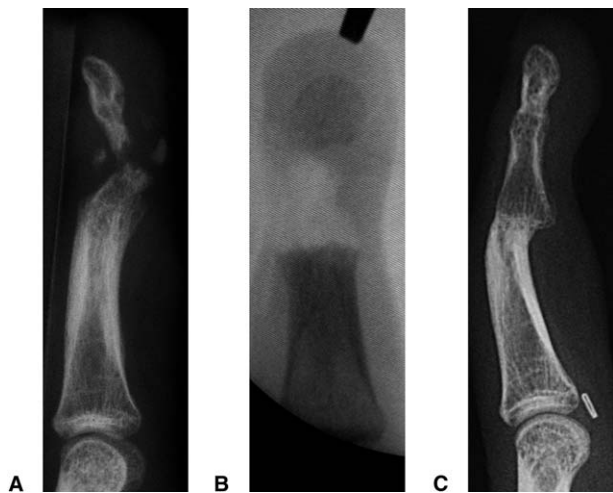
Destruction of the DIP joint and most of the distal phalanx in a case of chronic infection (patient 1). The PIP joint, at the bottom of the picture, is normal. (A) Preoperative x-ray. (B) Radial debridement: intraoperative fluoroscopy image. (C) Lateral x-ray taken 2 years after surgery.
